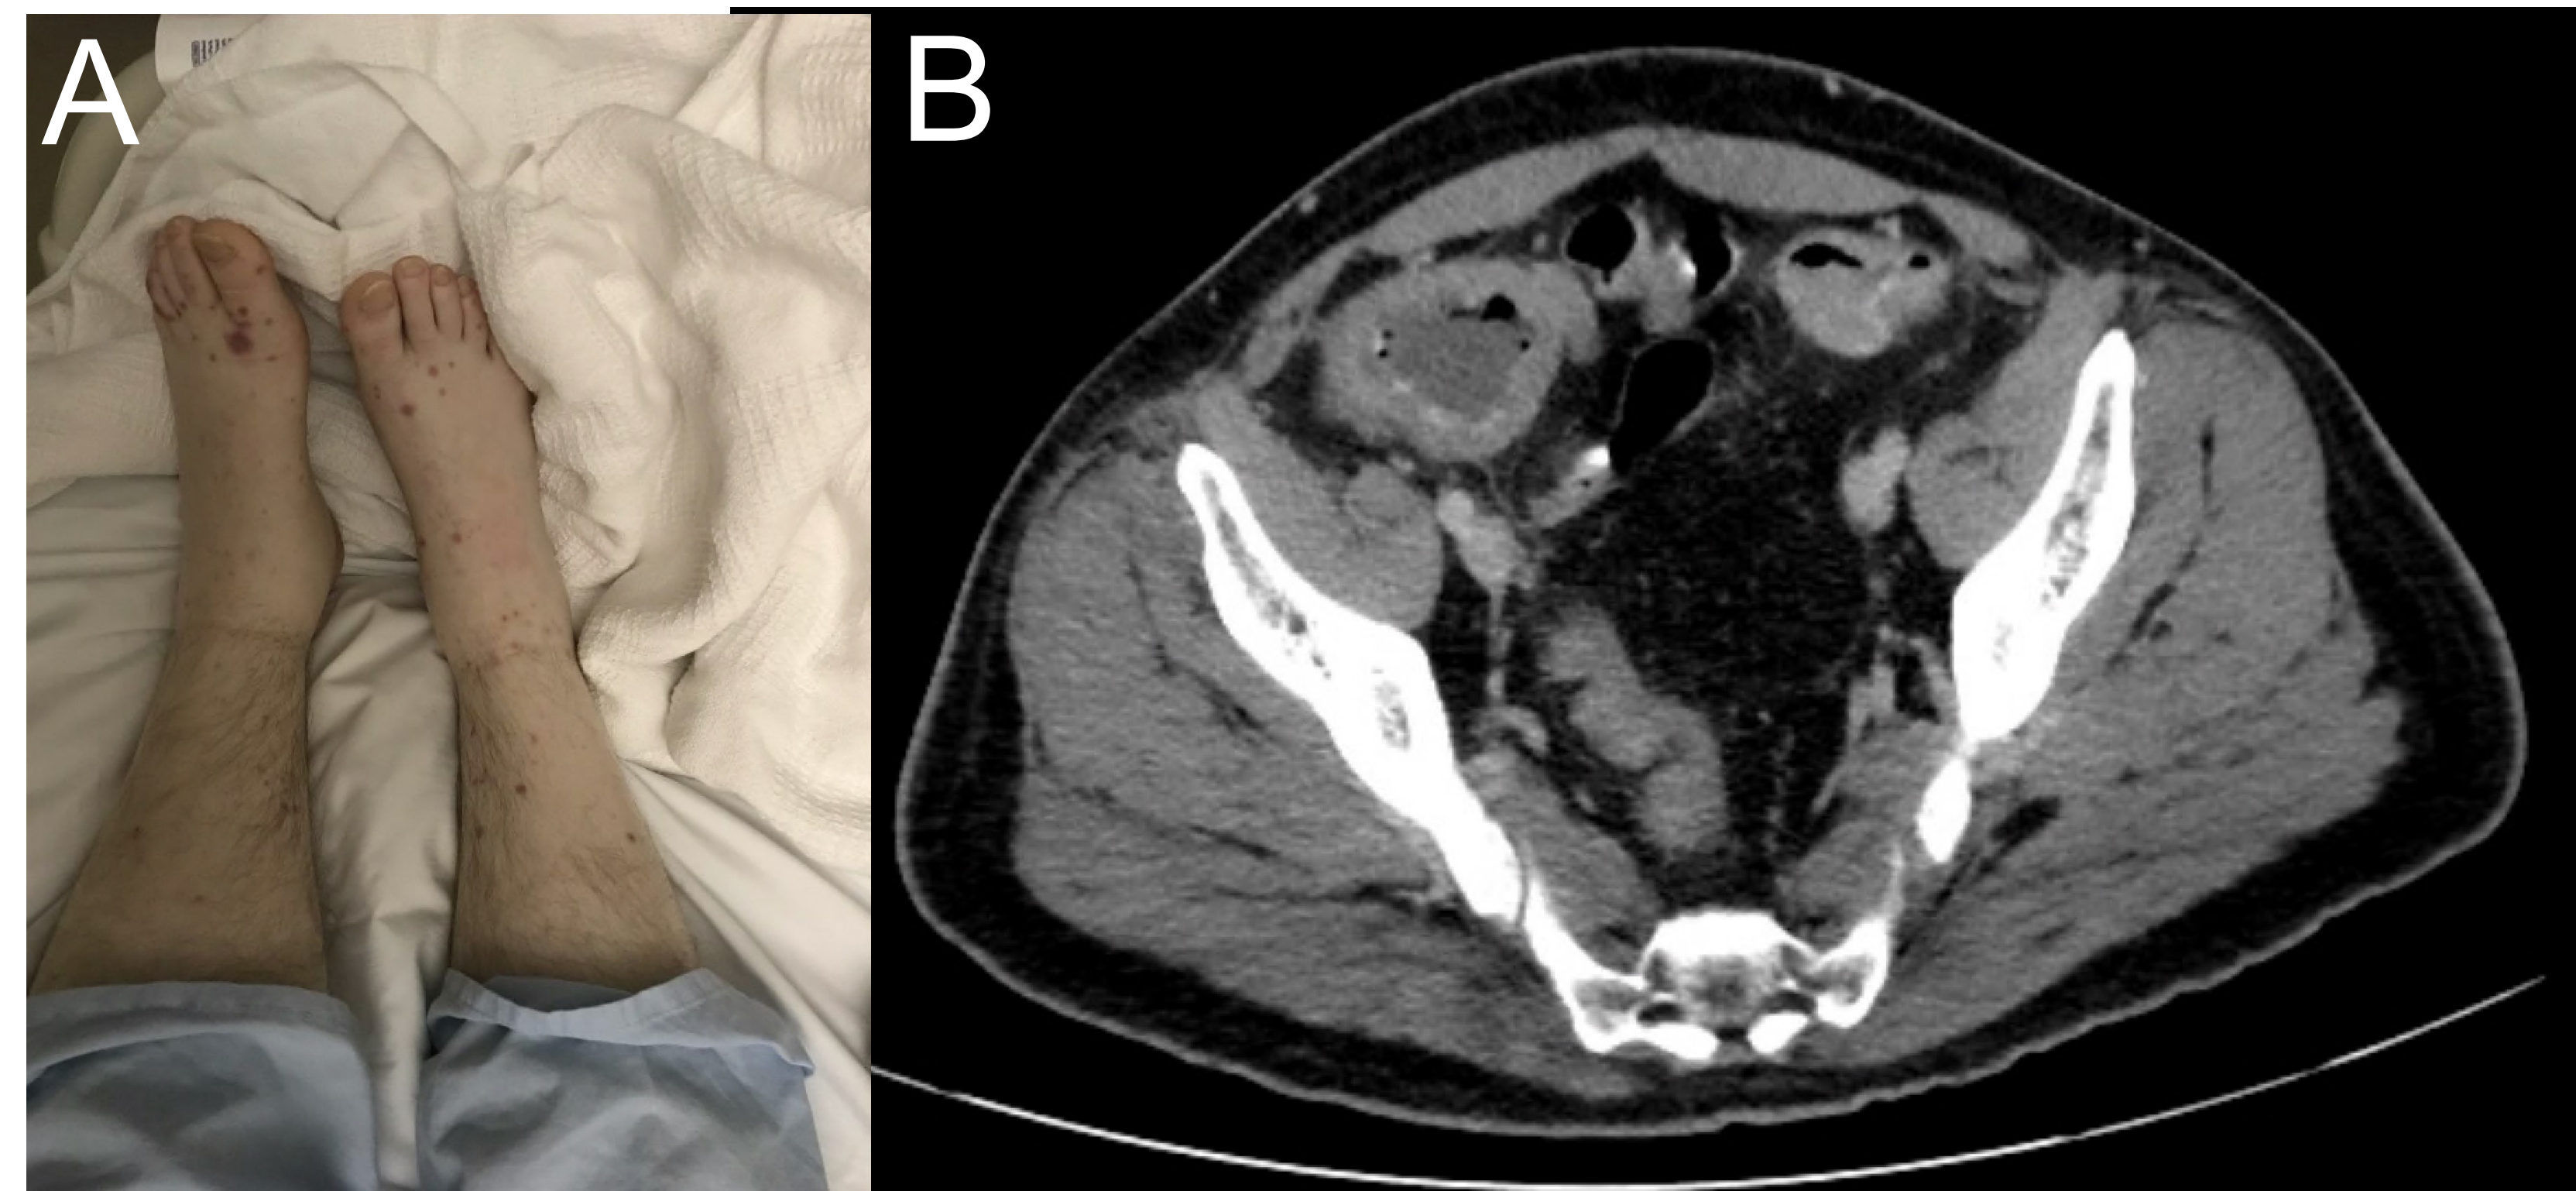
Initial presentation. Figure 1A. Image of nonpainful, nonpruritic purpuric rash on lower extremities. Figure 1B. CT scan with IV contrast showing diffuse colonic thickening with pericolonic fat stranding from the splenic flexure through rectum as well as in the cecum and ascending colon.
